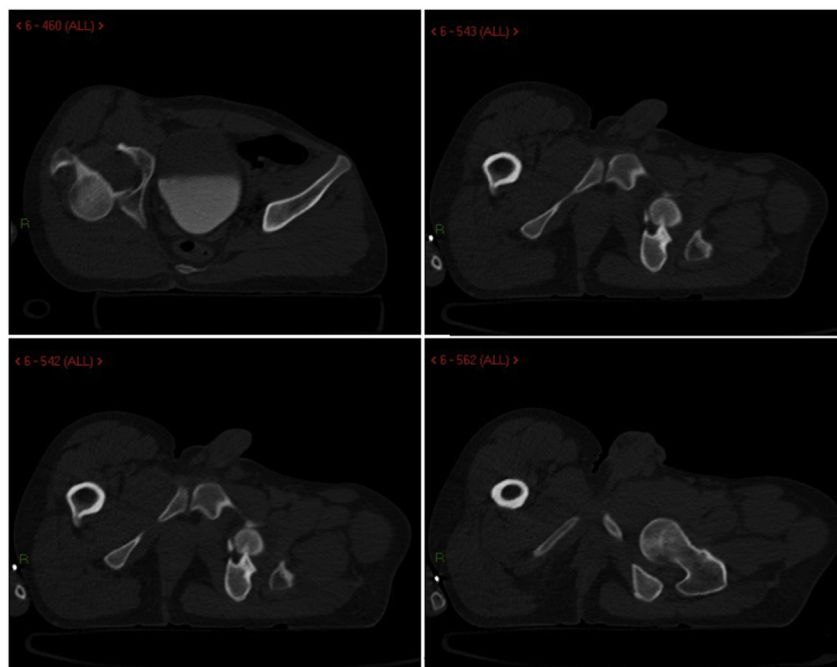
Pre-reduction CT scan.
